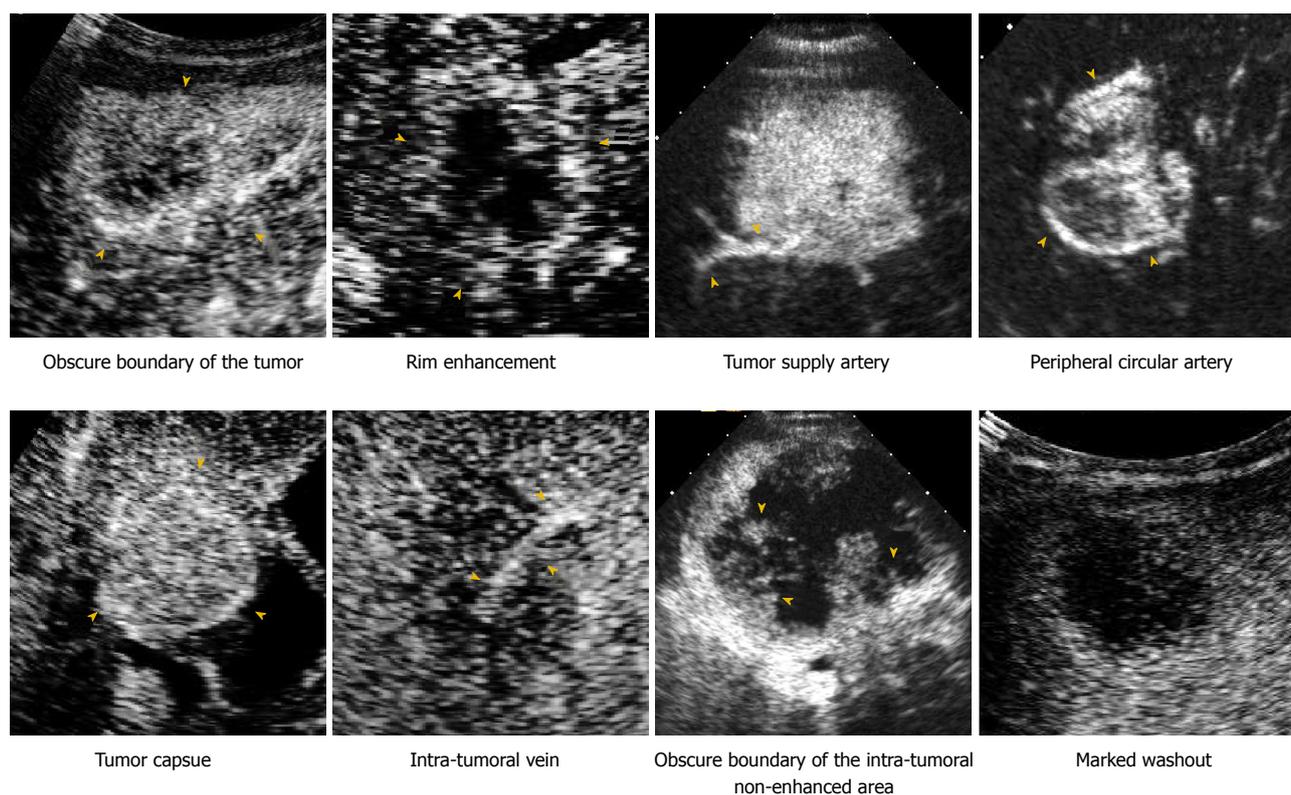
Contrast-enhanced ultrasound images demonstrate the enhancement features of intrahepatic cholangiocarcinoma and hepatocellular carcinoma.
